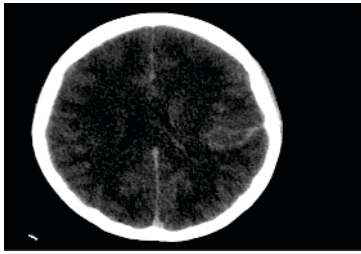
Contrast enhanced brain computed tomography (CT) revealing subtle loss of white-gray matter differentiation, indicative of diffuse cerebral edema.
